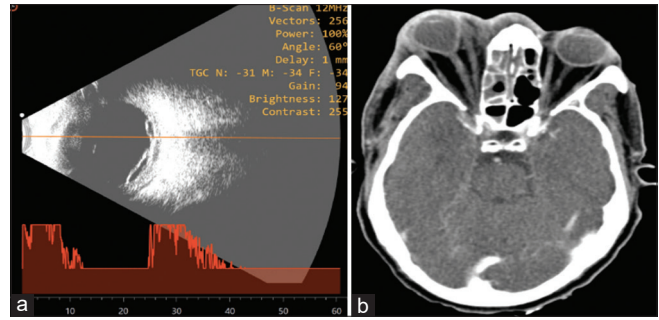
(a) Ultrasound B scan of the right eye showing exudative retinal detachment, thickening of the retina–choroid–sclera (RCS) complex and minimal subtenon fluid suggestive of scleral inflammation, (b) Contrast-enhanced computed tomography image showing pansinusitis with bony erosion of the medial orbital wall, with involvement of the medial and inferior extraconal spaces, and bulkiness of the medial and inferior rectus muscle
